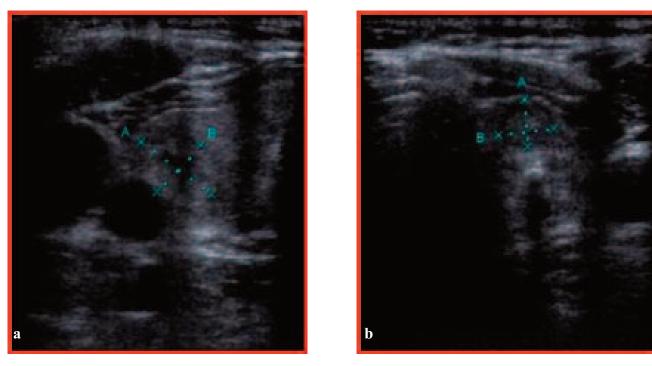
Ultrasound revealed one 10x7.5 mm solid nodule in the right lobe of thyroid (a), and one 7x5.5 mm solid nodule in the left lobe (b). These lesions were oval-shaped and had hypoechoic heterogeneous microstructures.
